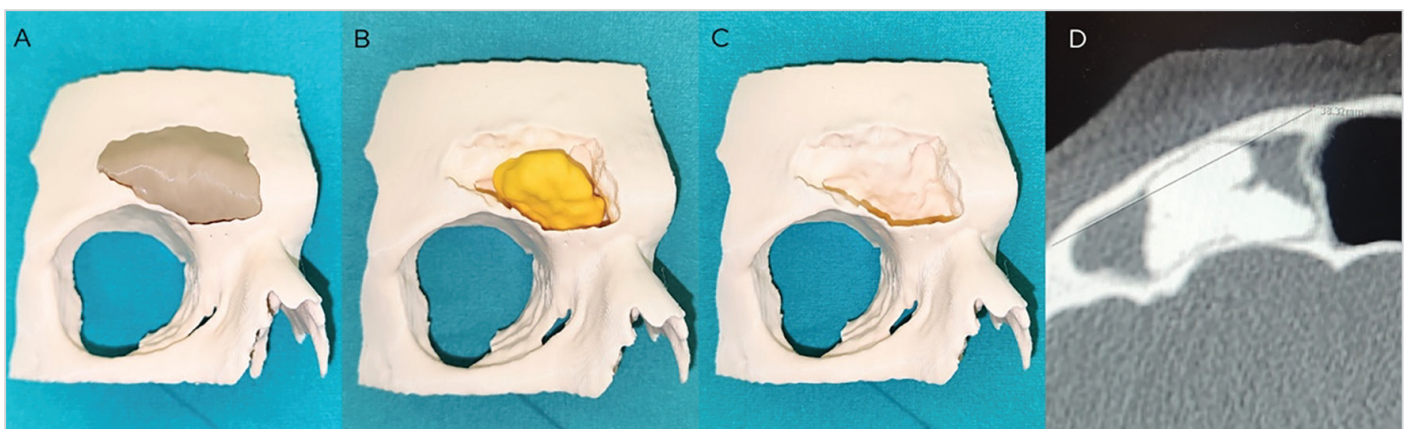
A) 3D model of the right frontal sinus and its anterior table, B) 3D model of the frontal sinus with the anterior table removed (the osteoma is shown in yellow), C) frontal sinus model with the osteoma removed, D) axial computed tomography image of the right frontal sinus
